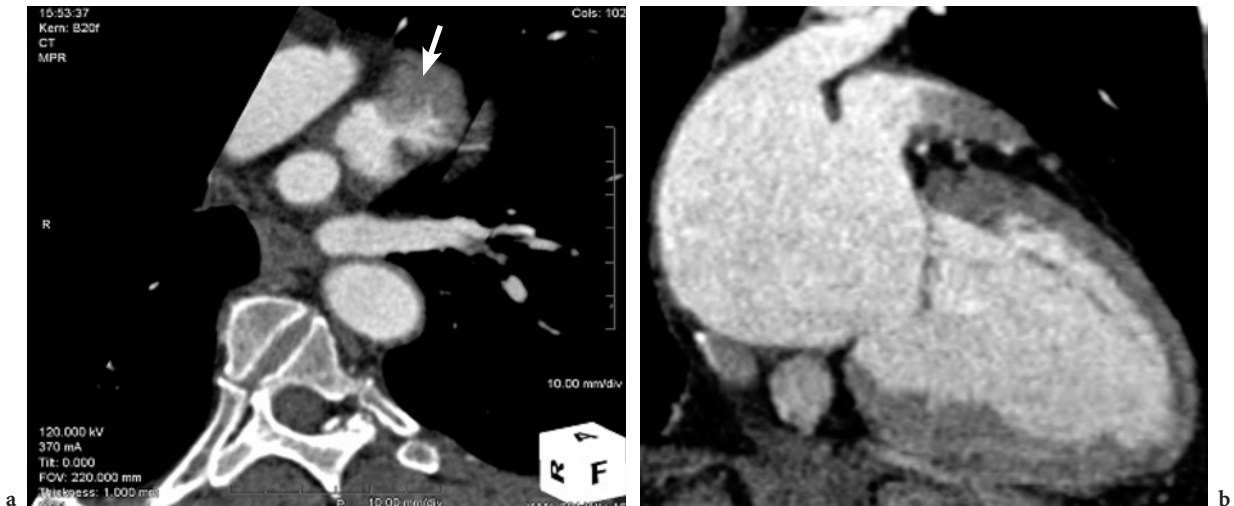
Left atrial appendage thrombus (*white arrow*) and a large left atrium in a patient with chronic atrial fibrillation on oral anticoagulant. a Axial view, b two-chamber view. Data were obtained using 16-slice CT with 16×0.75 -mm collimation and 0.42-s rotation time
